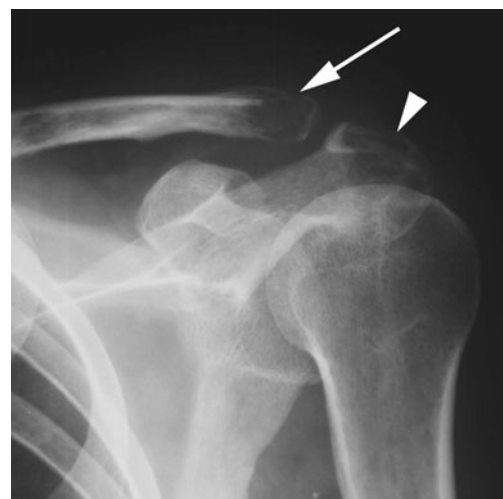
A 28-year-old woman with cervical, axillary, and supraclavicular lymphadenomegaly. Shoulder conventional x-ray showed osteolytic lesions in the acromion (arrowhead) and in the left clavicle extremity (arrow)
